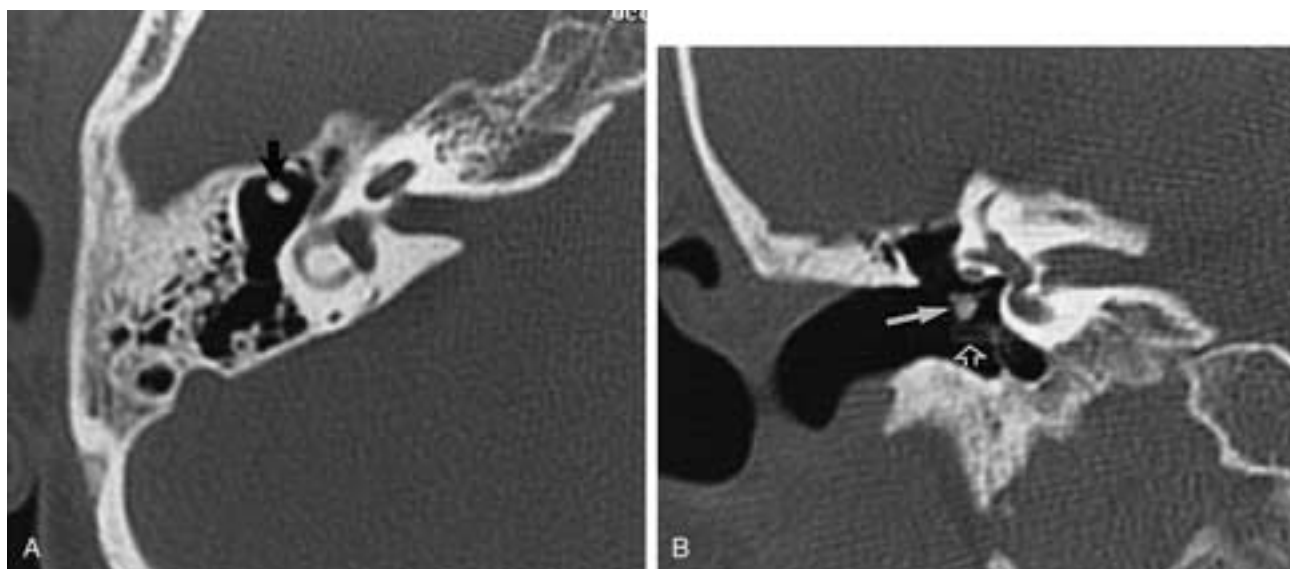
Incus interposition. A, Axial CT image shows the malleus head (*arrow*) in its normal position and absence of the incus from the attic. B, Coronal CT image demonstrates resculpted incus (*arrow*) extending toward the oval window. The stapes is not visualized on this image. Note the tympanostomy tube (*open arrow*).
